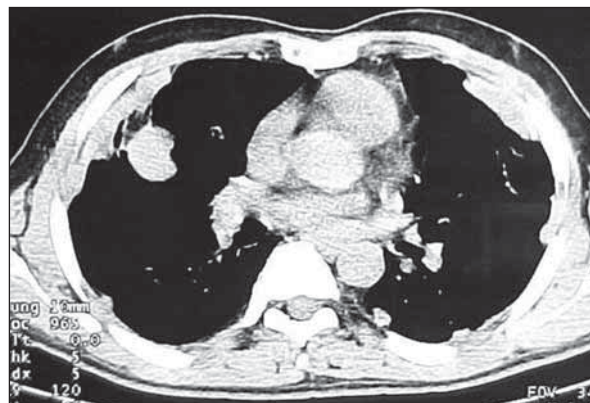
Chest CT demonstrating bilateral, extensive and multifocal pleural thickenings. Note that thickening of the right major fissure appears as a mass
